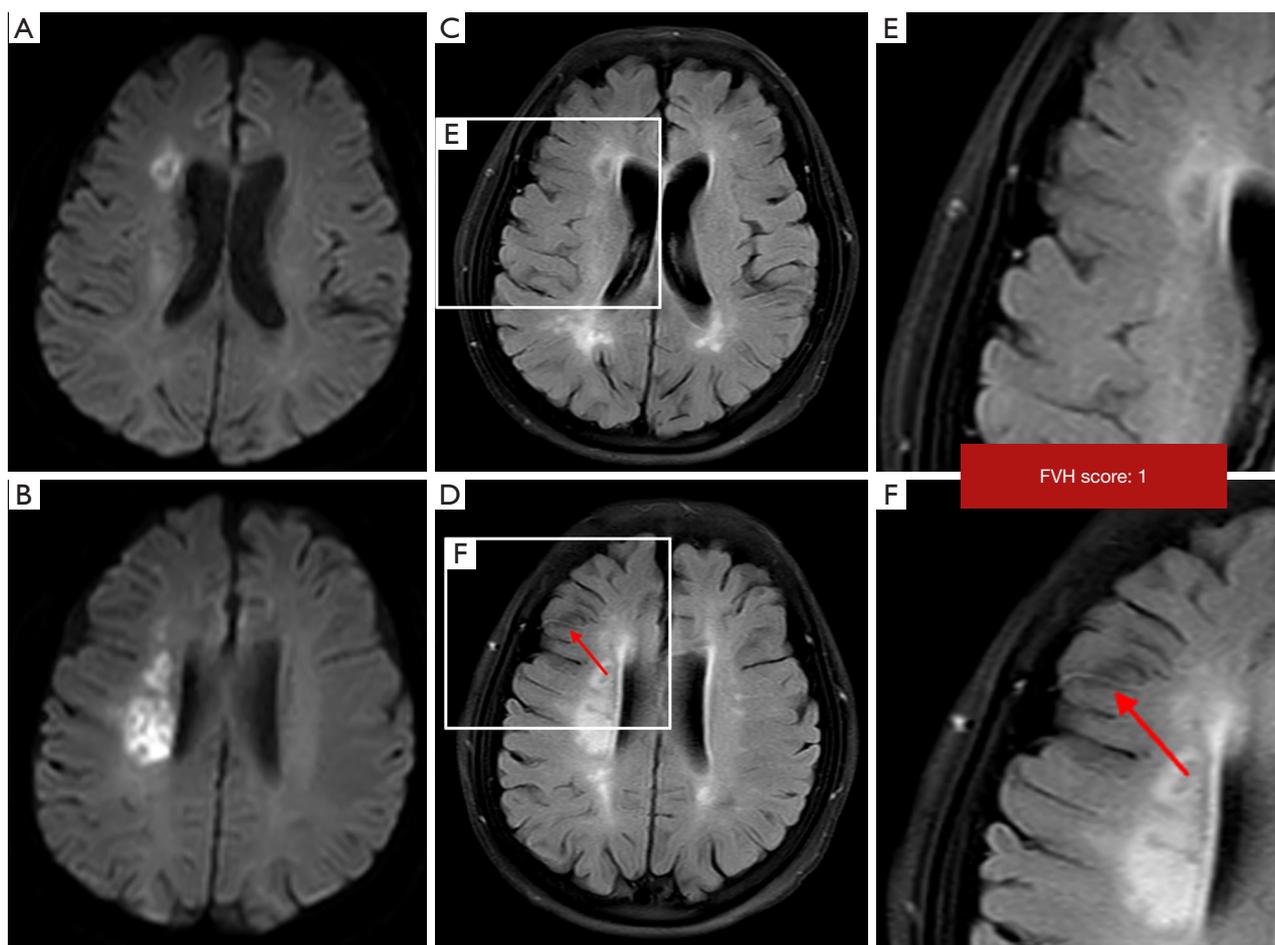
A no fluid-attenuated inversion recovery (FVH)-diffusion-weighted imaging (DWI) mismatch case. (A,B) Diffusion-weighted imaging (DWI) images and (C,D,E,F) fluid-attenuated inversion recovery (FLAIR) images. FVH facing the hyperintense cortex on DWI (red arrow). No FVH was found beyond the boundaries of the DWI lesion. The patient had no FVH-DWI mismatch. FVH was found in the M4, so the FVH score was 1.
